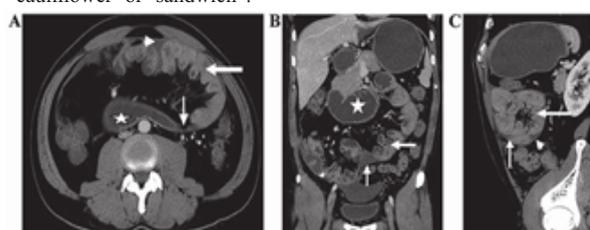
CT findings of abdominal cocoon disease.
